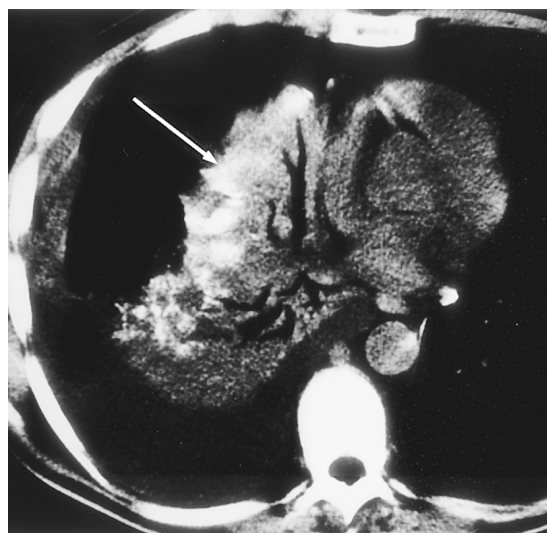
Nonenhanced CT scan shows occult portal vein invasion by the tumor as the thread and streak sign (arrowheads).
